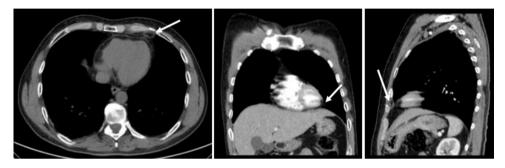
Thoracic computed tomography in April 2017, showing a reduction in the size of the paracardiac lesion (arrows).
